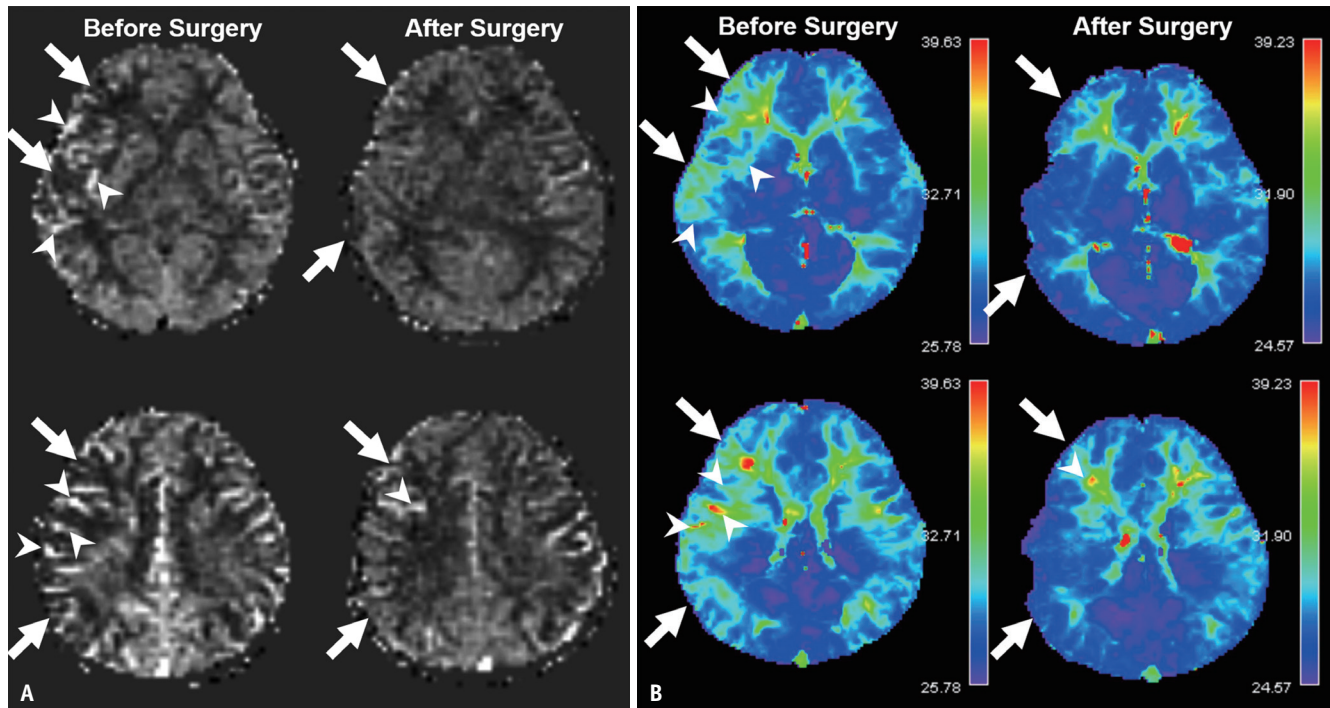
Good postoperative case. A 6-year-old girl underwent right encephaloduroarteriosynangiosis with good postoperative outcomes. A. Preoperative ASL perfusion image showing ATT effects (arrowheads) and no parenchymal signal areas (arrows) at the ganglionic and supraganglionic levels of the right MCA territory. Postoperative ASL images show decreased ATT effects (arrowhead) and improved parenchymal signal intensity (arrows) at the same level in the right MCA territory. B. Preoperative TTP maps of dynamic susceptibility contrast perfusion MRI showing a delayed TTP area in the right MCA territory (arrows) with several foci having delayed transit times (arrowheads) corresponding to the ATT areas on ASL images. Postoperative TTP maps show an improved TTP area in the operative MCA territory. Only a subtle delayed TTP area remained at the supraganglionic level with a delayed transit time (arrowheads) corresponding to the ATT area on the ASL image. ASL = arterial spin-labeling, ATT = arterial transit time, MCA = middle cerebral artery, TTP = time-to-peak
